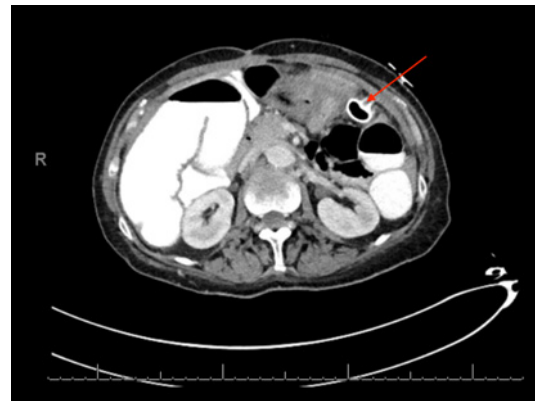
Post-hybrid gastrostomy placement axial CT showing successful placement (red arrow) in the previously identified narrow window.
